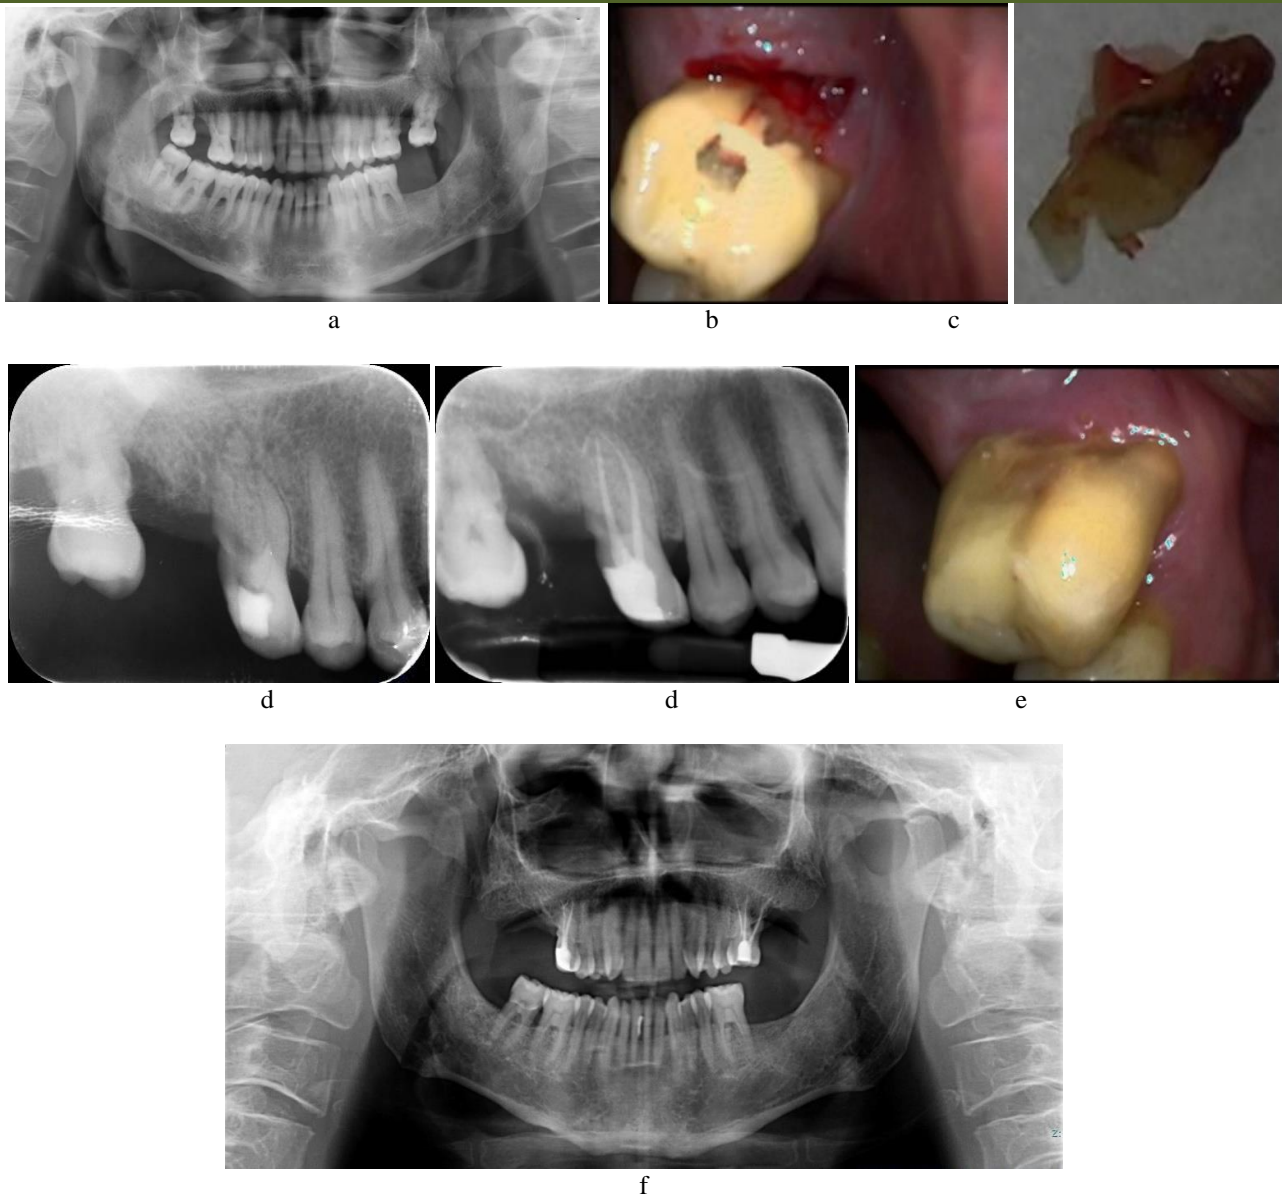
a. OPG done on the start of treatment on 2020. b & c. Root resection surgery photographs (August 2021). d. post root resection 16 periapical radiograph (December 2021) d. post RCT 16 periapical radiograph (August 2022) e. post root resection 16 Photo (March 2023). f. OPG after treatment of painful molars (September 2023)
